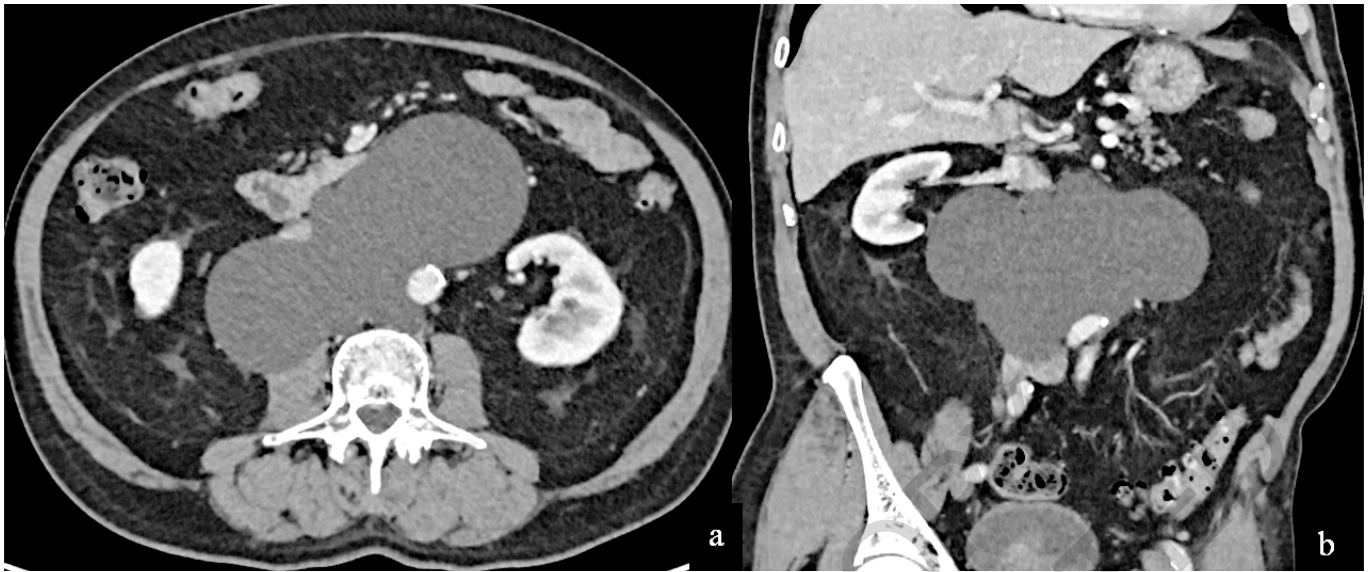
Cystic ganglioneuroma. Axial (a) and coronal (b) contrast enhanced CT images show a encapsulated homogeneous hypodense mass, between inferior cava vein and aorta. It has cystic appearance and it has been classified as cystic lymphangioma.
